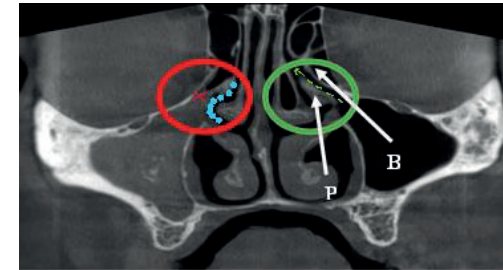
Assessment of OMU permeability based on CBCT. Coronal projection. Original collection
